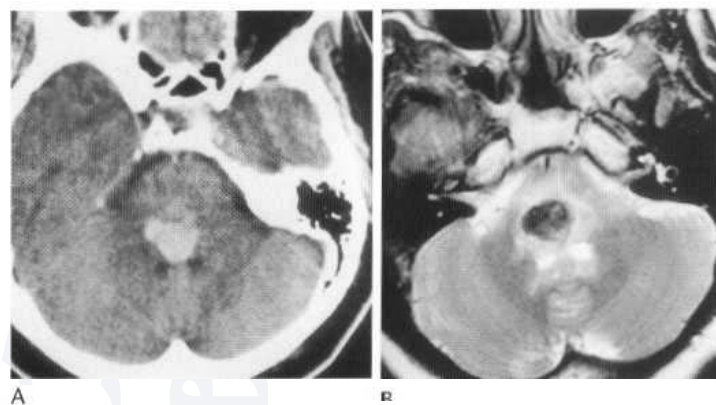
(A) Axial unenhanced CT and (B) T₂-weighted MR image demonstrating an acute intrinsic pontine haemorrhage.
